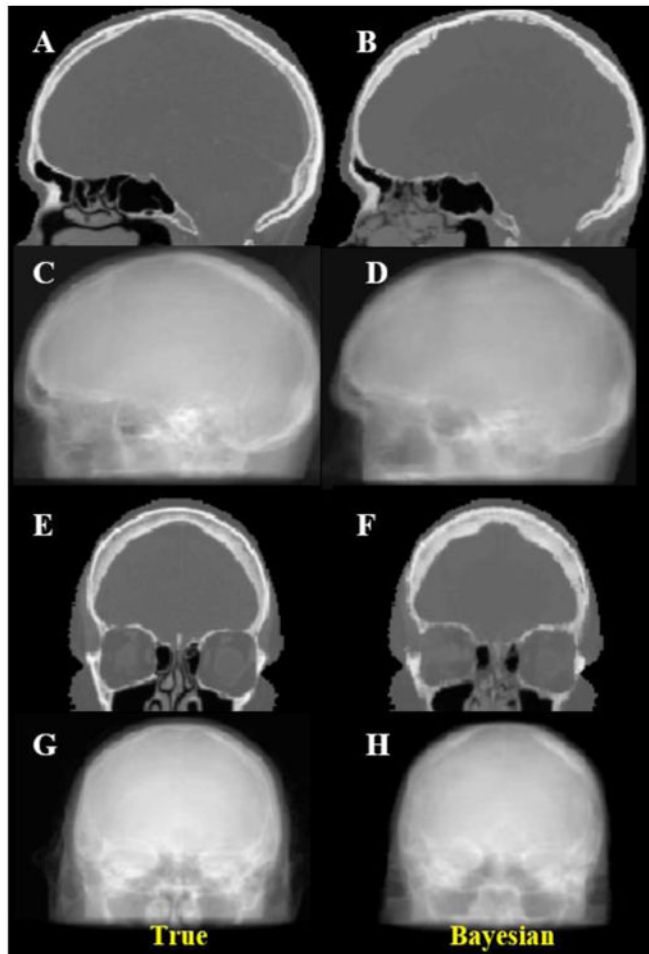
Sagittal (top half) and coronal (bottom half) views of true (left) CT scan and Bayesian estimated synthetic CT (right) and DRR images in two orthogonal views.
